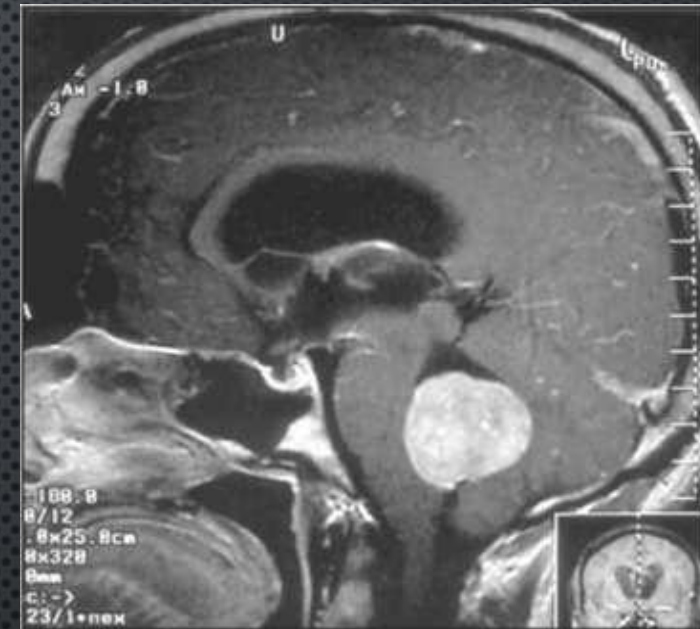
Sagittal T1 weighted MRI after contrast injection showing a midline cerebellar mass with posterior compression of the brain stem.
